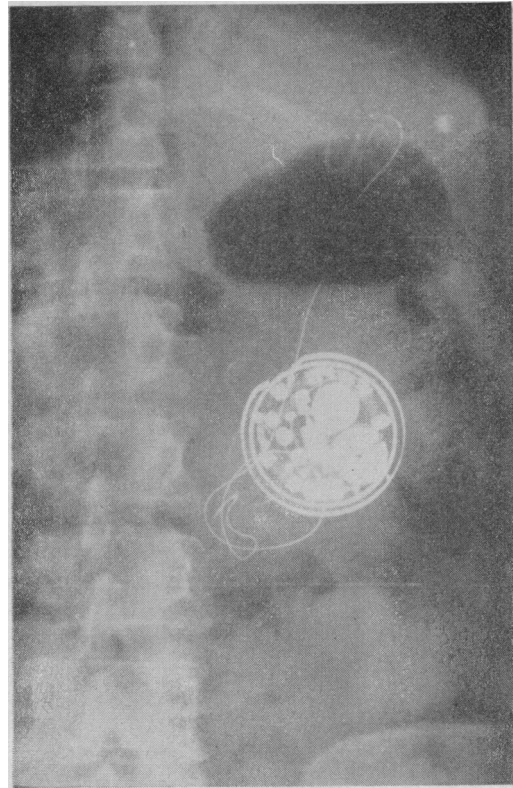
Abdominal X-ray showing pacemaker in abdominal wall with leads to the heart
